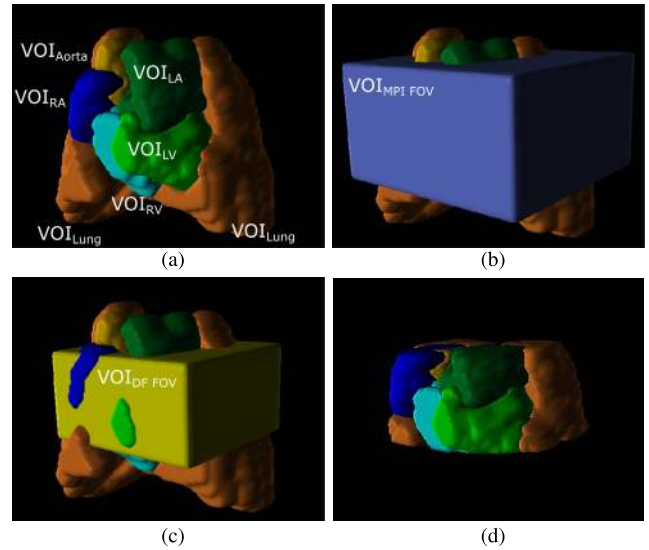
MR-derived VOIs of the right atrium (RA), right ventricle (RV), left atrium (LA), left ventricle (LV), as well as the lungs. The manual segmentation was performed on the high-spatial resolution coronal MRI dataset. Each VOI is presented in a color-coded volume rendered representation. (a) depicts the complete anatomical VOIs (b) furthermore presents the reconstructed MPI-FoV, while (c) presents the DF-FoV defining the confidence interval of the reconstructed MPI data, while (d) shows the MR-derived VOIs cropped along the DF-FoV. The cropped VOIs were used in this study for MPI data analysis.
